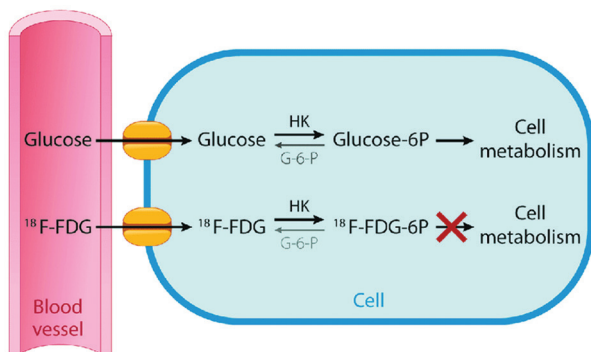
Abnormal uptake and metabolic scavenging of 2-deoxy-2-[fluorine-18]fluoro-D-glucose (¹⁸F-FDG) in inflammatory or neoplastic cells, comparing to glucose. Available via license: “<https://creativecommons.org/licenses/by-nc-nd/4.0/>”
